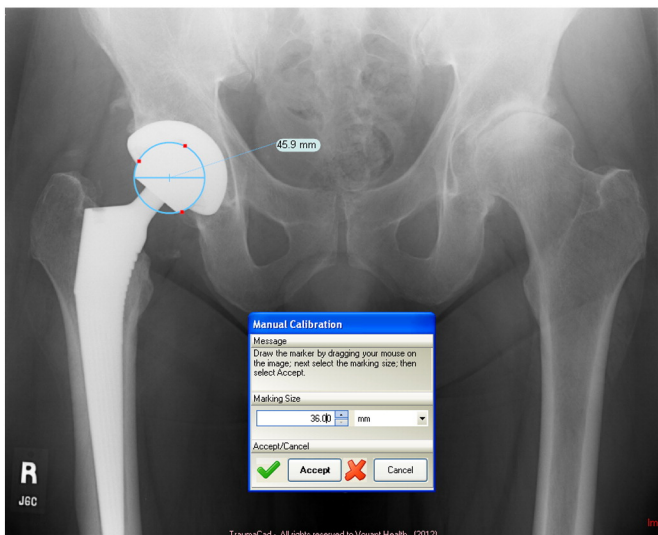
Calibration of the AP pelvis view radiographs.
